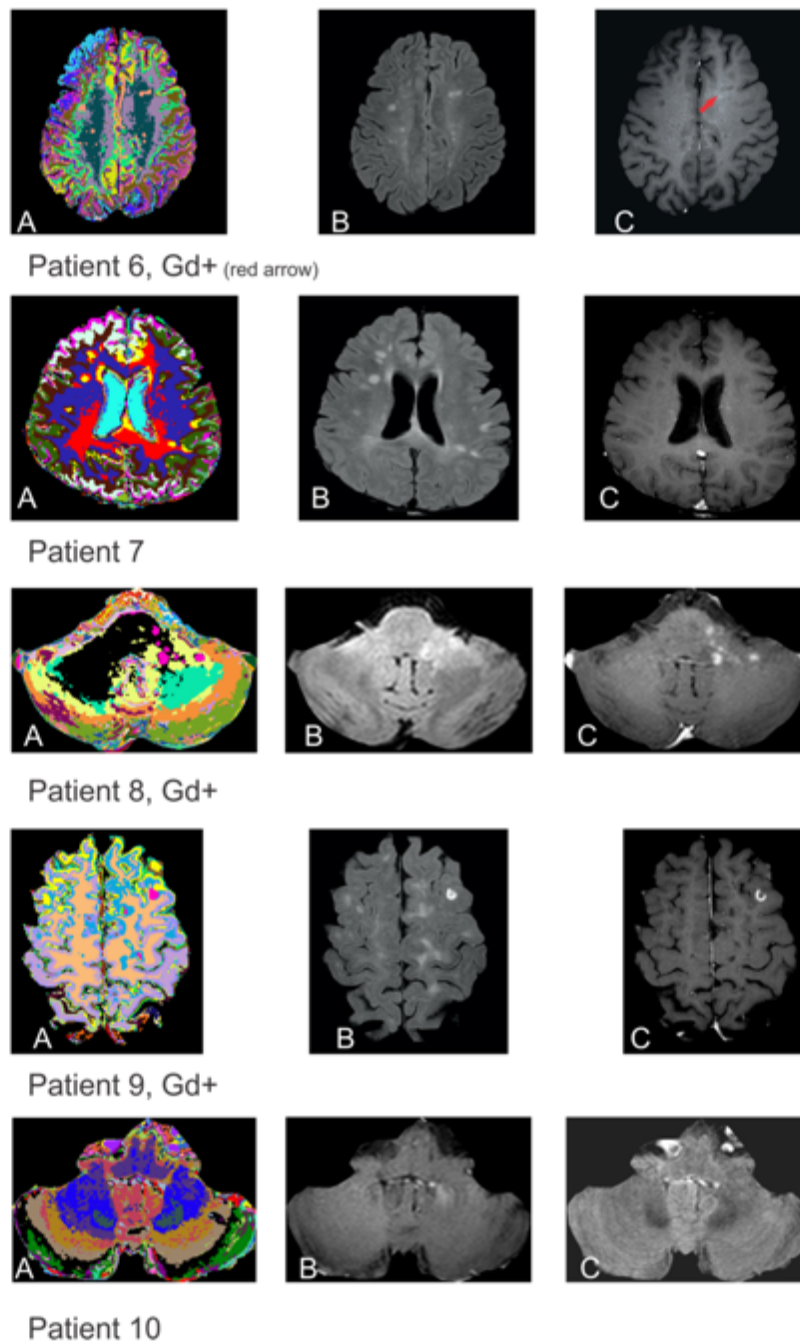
(contd.) – For each patient, A – SOM generated image, B – FLAIR, and C – Gadolinium T1 acquisitions. Gd+ = Patient with Gd enhancement. On Patient 6 the area of enhancement (shown by red arrow) is better seen in other acquisitions, not displayed here
